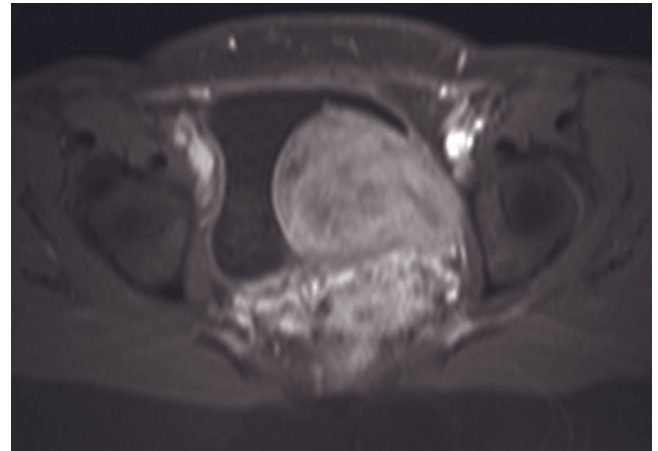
Leiomyoma. Coronal (a), sagittal (b), and transverse (c) 512-resolution T2-weighted ETSE, transverse T1-weighted SGE (d), immediate transverse T1-weighted gadolinium-enhanced SGE (e), and delayed (2 min) transverse T1-weighted gadolinium-enhanced SGE (f) and sagittal (g) T1-weighted gadolinium-enhanced fat-suppressed SGE images demonstrate a large mass involving the left lateral wall and trigone of the bladder. The mass is hypointense on T2 (a-c)- and T1 (d)-weighted images, reflecting low fluid content characteristic for leiomyomas. There is mild heterogeneous enhancement on the immediate gadolinium-enhanced T1-weighted image (e), with progressive enhancement on the delayed images (f, g).
